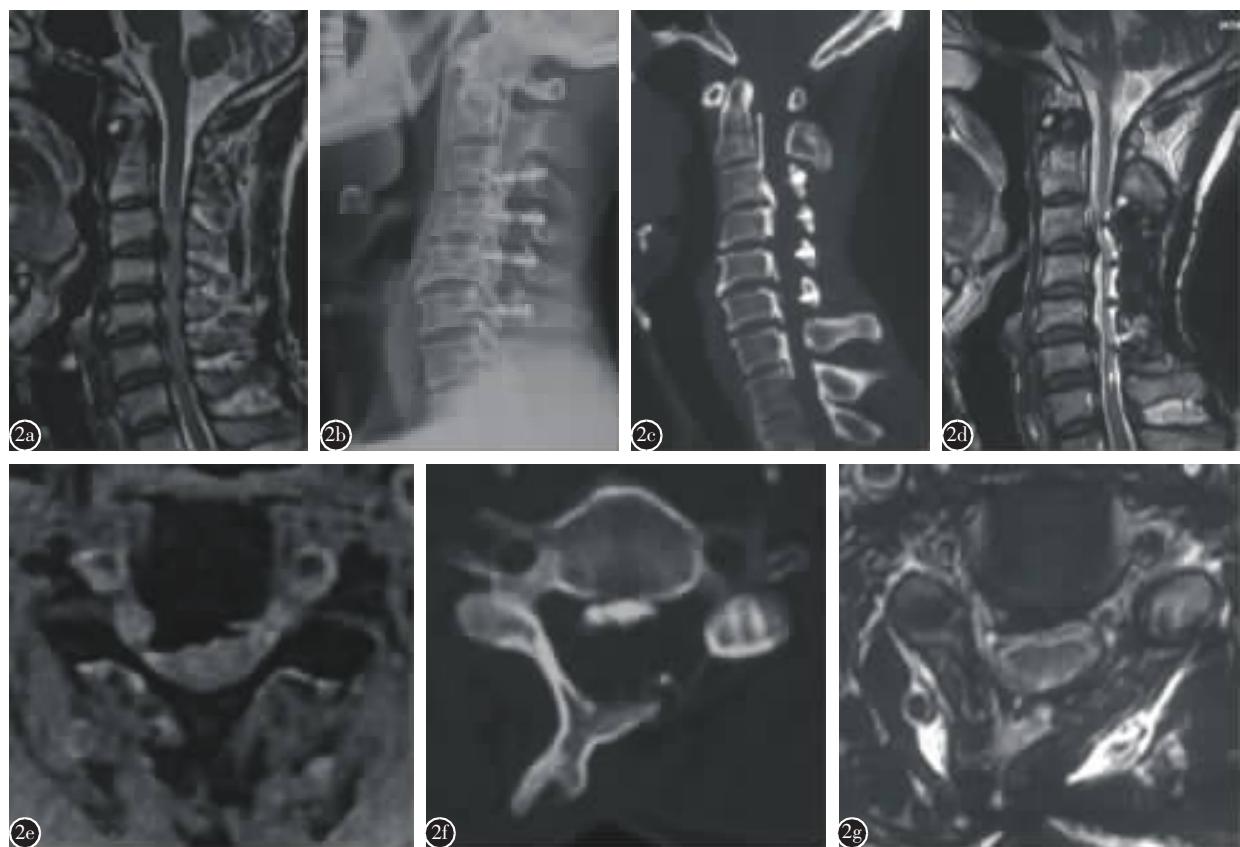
LAM 病例术前及术后影像 a 术前 MRI 矢状面 b 术后 X 线侧位片,示减压 C3-C6 c 术后 CT 矢状面 d 术后 MRI 矢状面 e 术前 C5 节段 MRI 横断面 f 术后 C5 节段 CT 横断面,示椎管空间在左背侧扩大 g 术后 C5 节段 MRI 横断面,示脊髓向左背侧漂移,两侧神经根走行不对称
